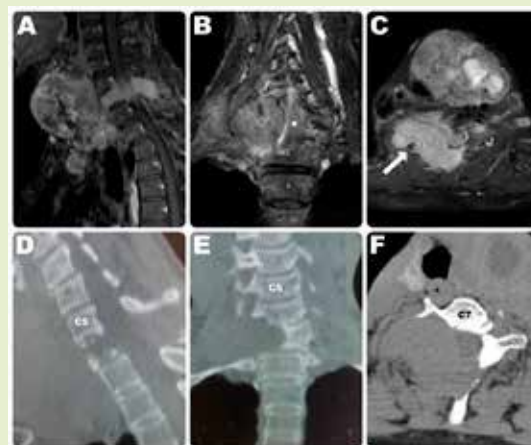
Post contrast cervical MRI images obtained before surgery (a–c). a) Sagittal image. b) Coronal image with star representing spinal cord compressed by spinal tumor. c) Axial image, white arrow showing vertebral artery encased by spine tumor. CT images (d–f) Osteolytic destruction of C6 & C7 vertebral body.
